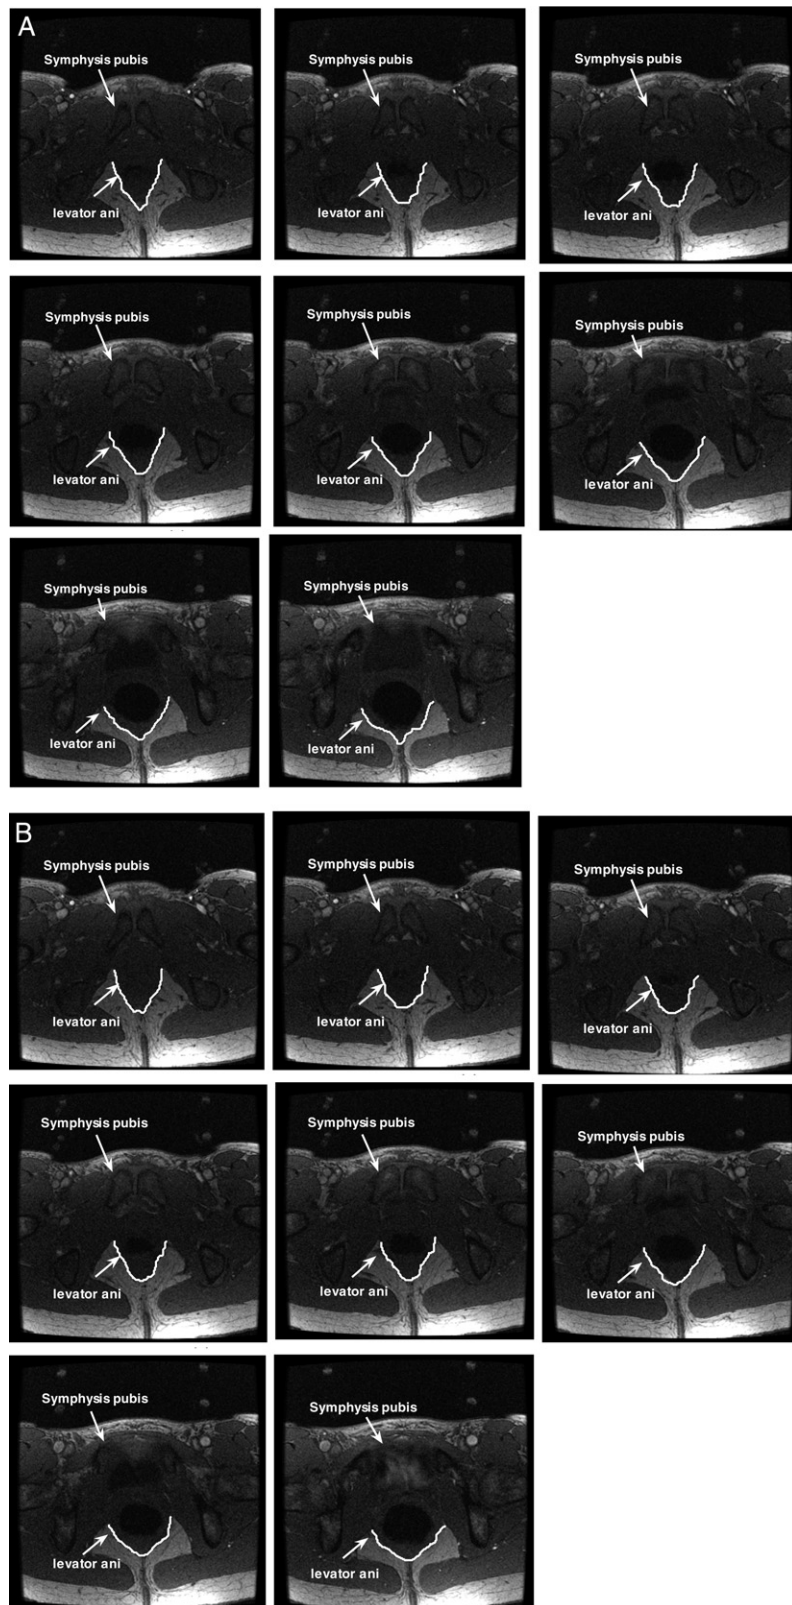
A, T1-weighted axial image of 47-year-old participant with manual segmentation of LA at rest. B, T1-weighted axial image of same participant with manual segmentation of LA during voluntary contraction.
